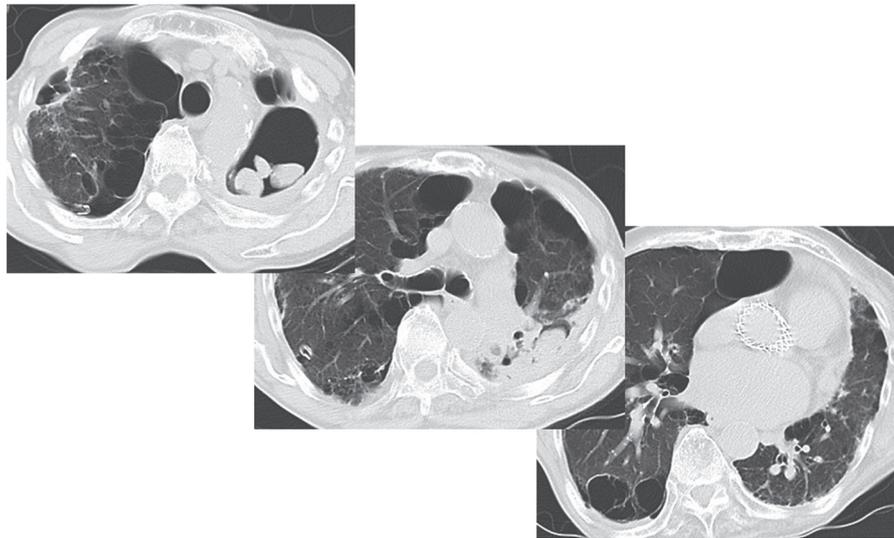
Chest CT after chest drainage showed bullous change and shadow of aspergilloma and NTM in the left lung.
